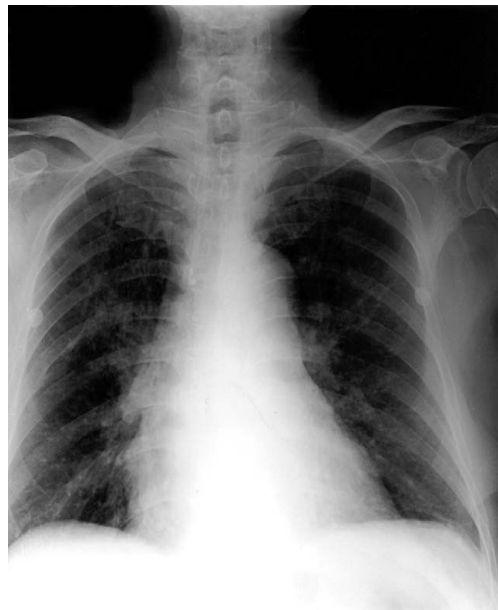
Case 1: posteroanterior radiography shows axial interstitial pattern of bilateral lung fields.
